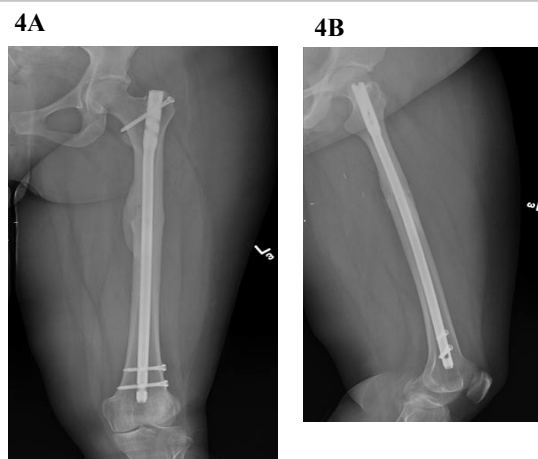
Radiographs depicting successful healing of the femoral shaft fracture following intramedullary nailing.
